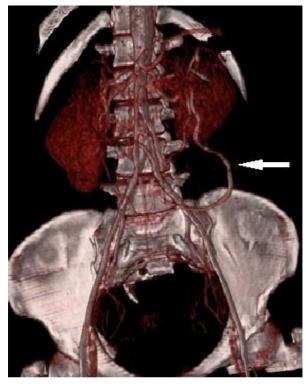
CT Angiogram of the abdominal aorta (false colour picture with 3D reconstruction)
